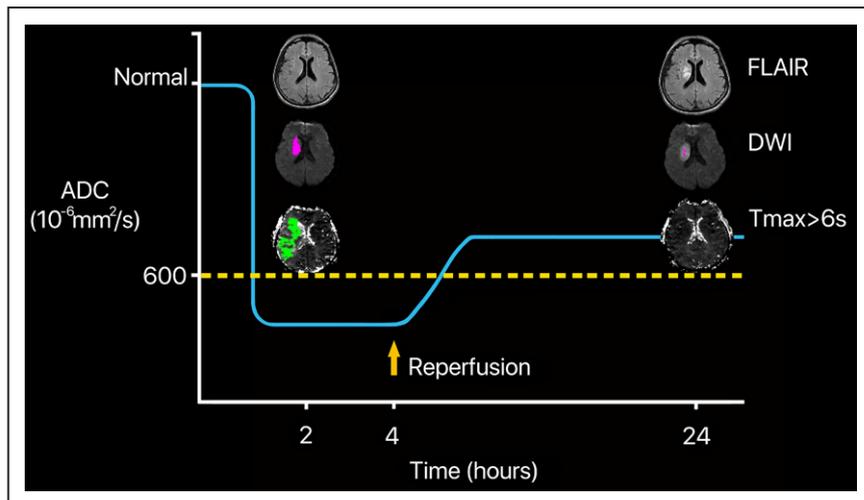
The first set of 3 images was obtained 2 hours after symptom onset in a patient with an acute right middle cerebral artery (MCA) occlusion. The top image, a FLAIR sequence is normal; however, the diffusion-weighted lesion (DWI) map, identifies regions of severe ischemia with low apparent diffusion coefficient (ADC) values adjacent to the right lateral ventricle (shown in pink). On the $T_{\text{max}} > 6$ perfusion image, shown immediately below the DWI map, the green region corresponds to a large portion of the MCA vascular territory with severe hypoperfusion. Four hours after symptom onset, the patient experienced complete reperfusion of the MCA occlusion. After reperfusion, the ADC values (shown by the blue line) rise to levels above the ADC threshold (shown with a dotted yellow line) therefore the complete DWI lesion no longer has a low ADC (pink color almost disappears) but typically will still be visible as a bright lesion on both the DWI and FLAIR map.
